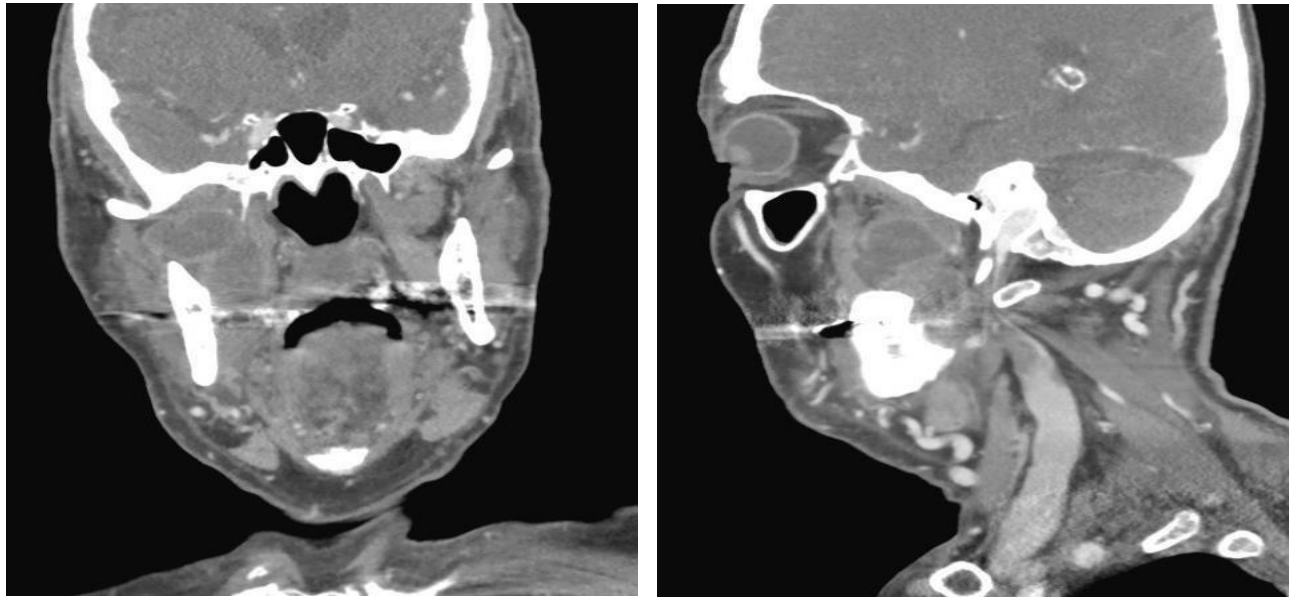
A) Coronal CT shows a bilobed infratemporal fossa mass
